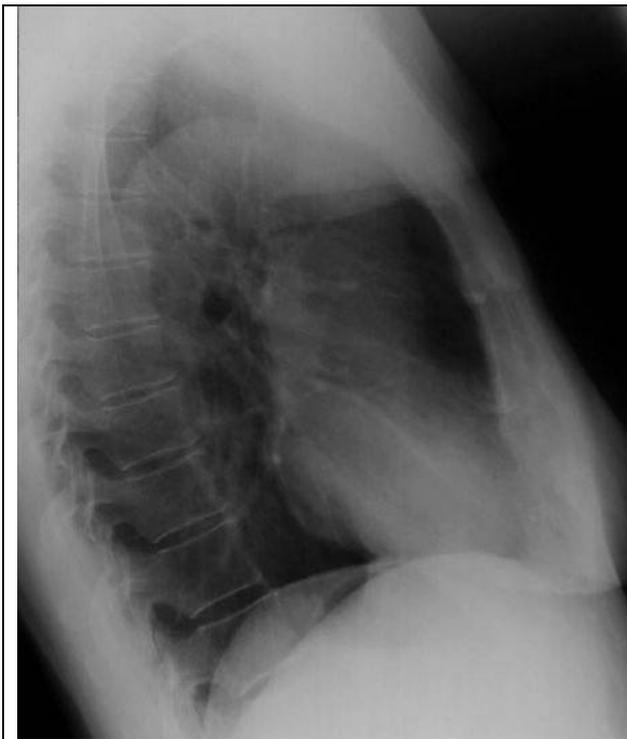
Chest radiograph, right lateral projection
